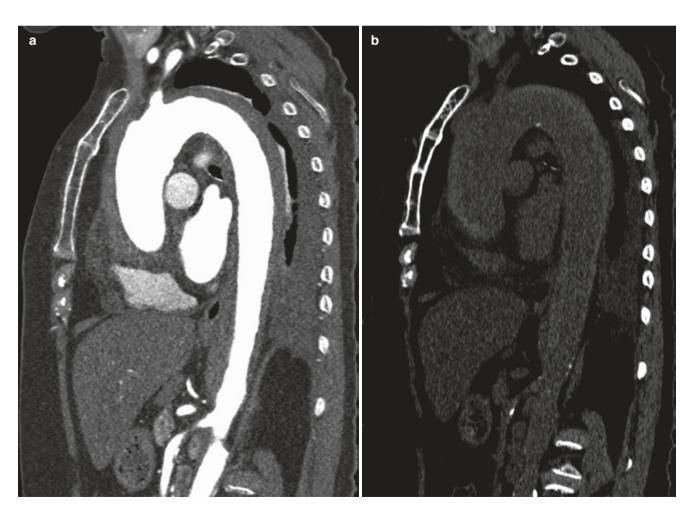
Utility of dual-energy CT in intramural hematoma. (a) Sagittal contrast-enhanced dual-energy CT—underlying acute intramural hematoma masked by the contrast. (b) Sagittal virtual non-contrast
